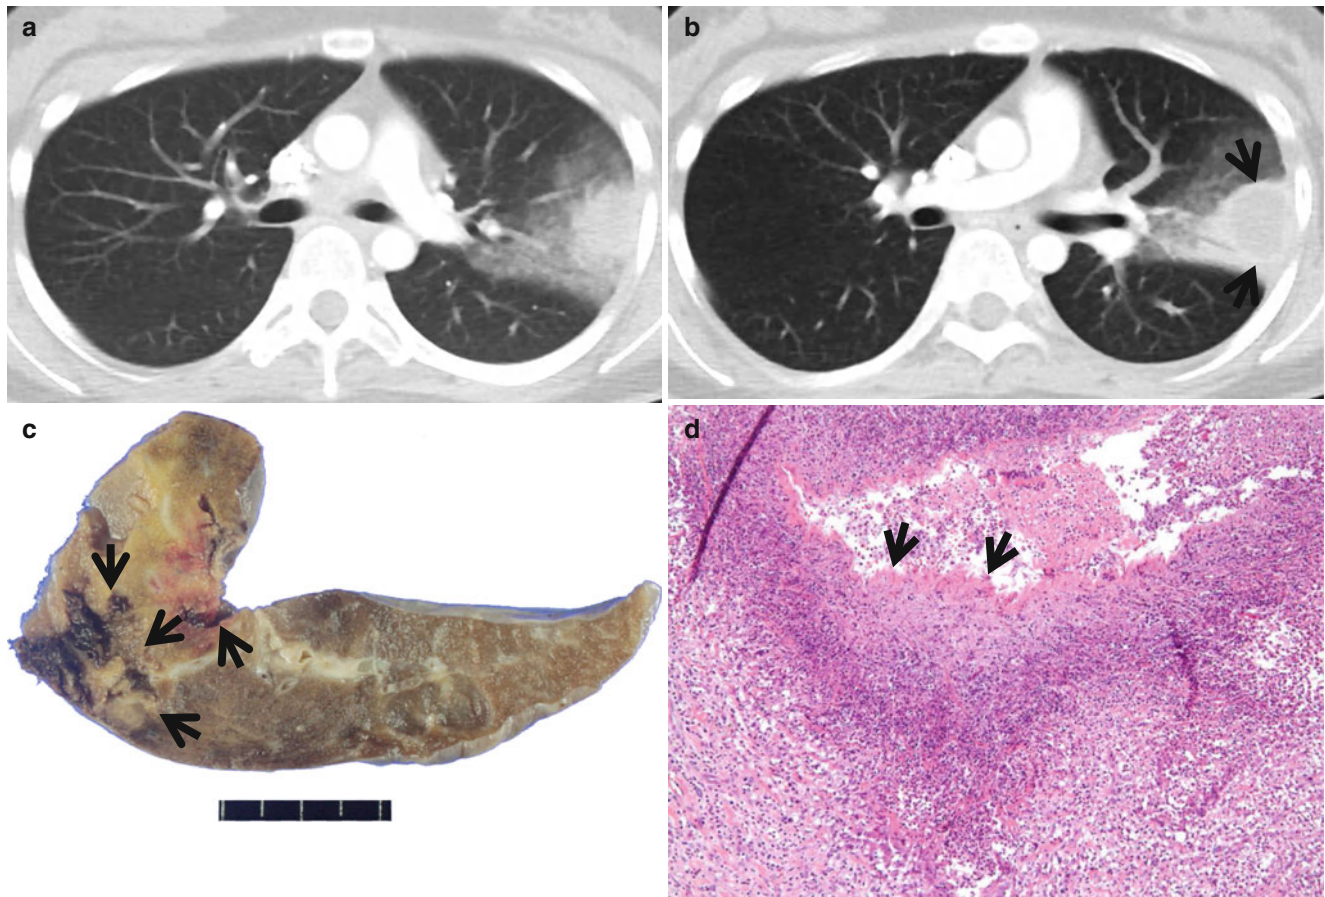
Pulmonary mucormycosis in a 17-year-old woman who had a history of anaplastic large cell lymphoma 5 years ago. (a, b) Lung window images of enhanced consecutive CT scans (5.0-mm section thickness) obtained at levels of the right bronchus intermedius show dense consolidation surrounded by ground-glass opacity (a kind of halo sign). Please note internal reversed halo sign (arrows) formed by central necrosis and peripheral enhancing ring of consolidation. (c) Cut surface
